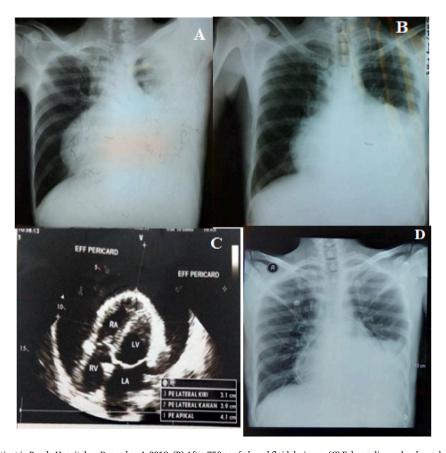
(A) First-time patient in Bunda Hospital on December 4, 2019, (B) After 750 cc of pleural fluid drainage, (C) Echocardiography showed massive pericardial effusion, (D) After 600 cc of pericardial fluid drainage.
